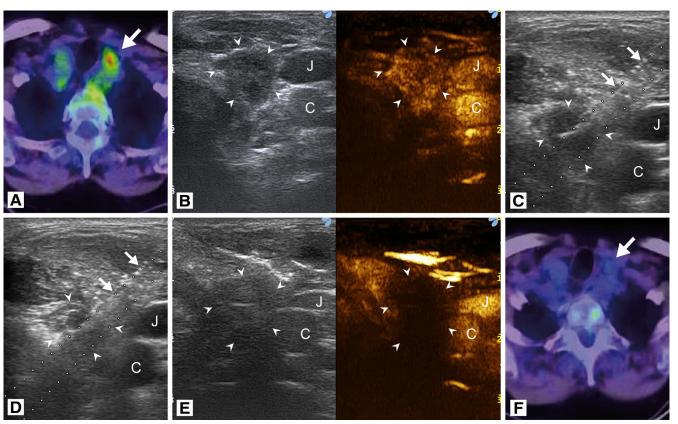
Percutaneous laser ablation of a metachronous cervical lymph node metastasis. Panel A, Preprocedural ¹⁸FDG-PET/CT demonstrated high uptake in a lymph node in the neck (arrow) in a patient previously treated with total thyroidectomy and ¹³I ablation for a papillary thyroid carcinoma. Panel B, CEUS demonstrated an 11-mm lymph node (arrowheads) with enhancement at the same level. Panel C, The lymph node (arrowheads) was treated by a percutaneous laser ablation under US guidance by 1 fiber insertion (arrows indicate needle with laser fiber). Panel D, Ultrasound monitoring of the procedure demonstrated gas formation at the level of the lymph node (arrowheads) during ablation (arrows indicate needle with laser fiber). Panel E, CEUS performed immediately after the ablation demonstrated a complete lack of enhancement at the level of the treated lymph node (arrowheads). Panel F, Follow-up ¹⁸FDG-PET/CT demonstrated absence of uptake at the level of the treated lymph node (arrow). Abbreviations: C, carotid artery; J, jugular vein.
